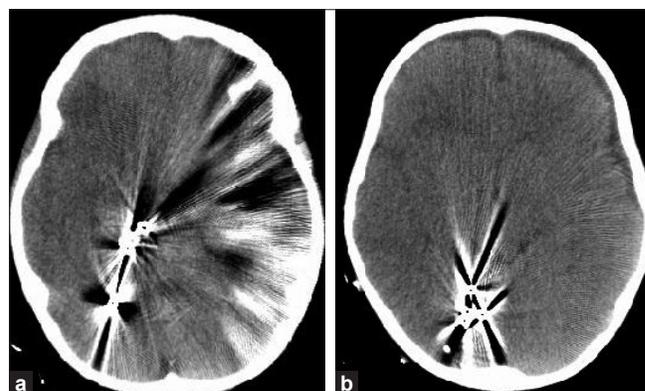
Axial consecutive CT images show multiple hyperdense birdshots with streak artifacts within the posterior fossa (a) and the occipital lobe (b). No prominent intraparenchymal hemorrhage is seen. Note the small amount of subdural effusion over the left frontal lobe
